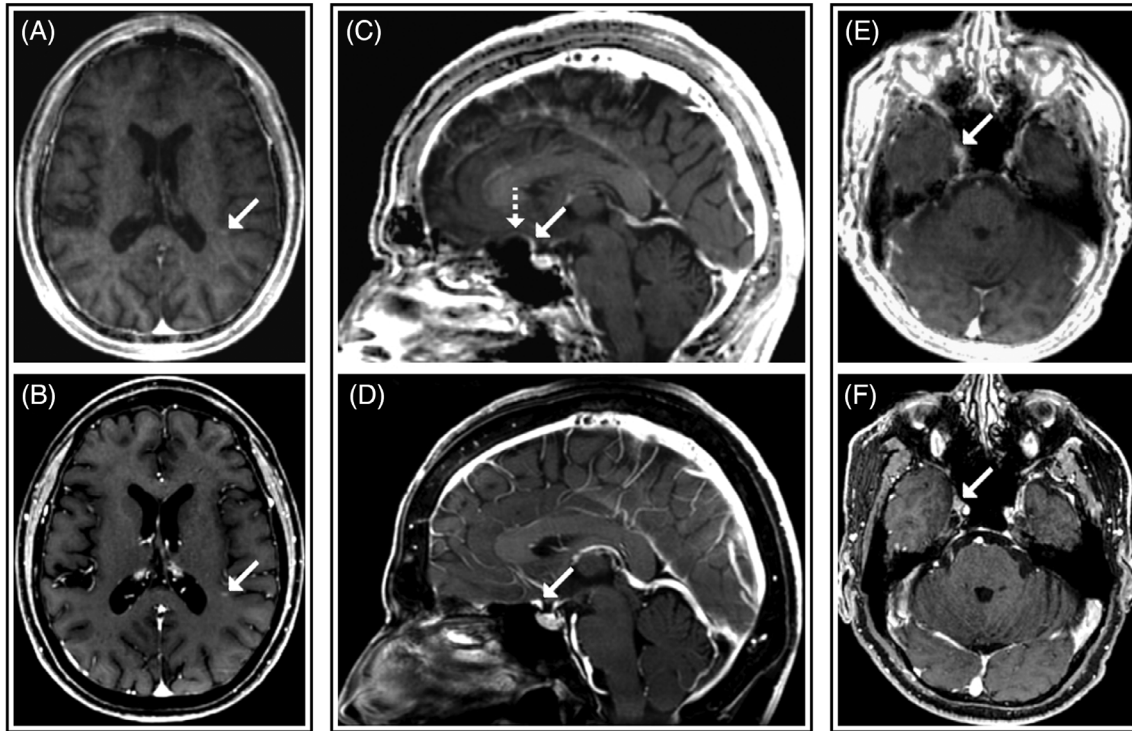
Examples of discrepancies in enhancing lesions visibility between synthetic (A, C, and E) and conventional (B, D, and F) post-contrast T1-weighted imaging. A-B: Contrast enhancing demyelinating lesion in a patient with multiple sclerosis (arrows). The small lesion was visible in conventional images but failed to be detected in synthetic images. C-D: Meningioma at the level of the jugum sphenoidale (arrows) visible in conventional images (D) but missed in the blinded assessment of synthetic images (C); in the latter, the artifact at the air-tissue interface (dashed arrow in C) reduced the lesion conspicuity. E-F: Meningioma at the level of the cavernous sinus (arrows). The lower spatial resolution of synthetic images (E) reduced the visibility of the lesion, which was not clearly distinguished from the internal carotid artery.
